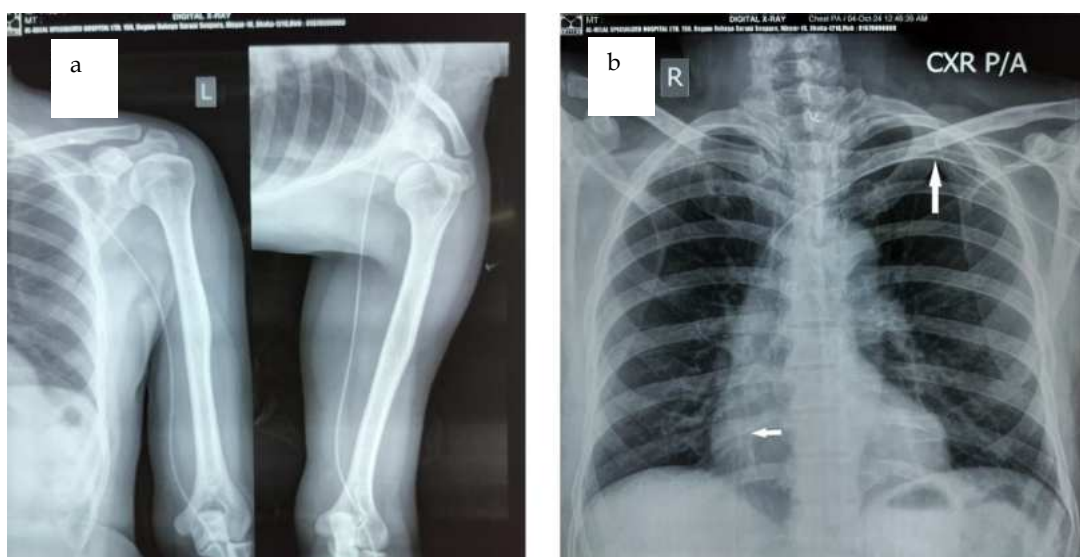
Preoperative X-ray showing peripherally inserted central catheters with the retained guidewire: a) left arm, b) chest (arrows indicate guidewire's position)
